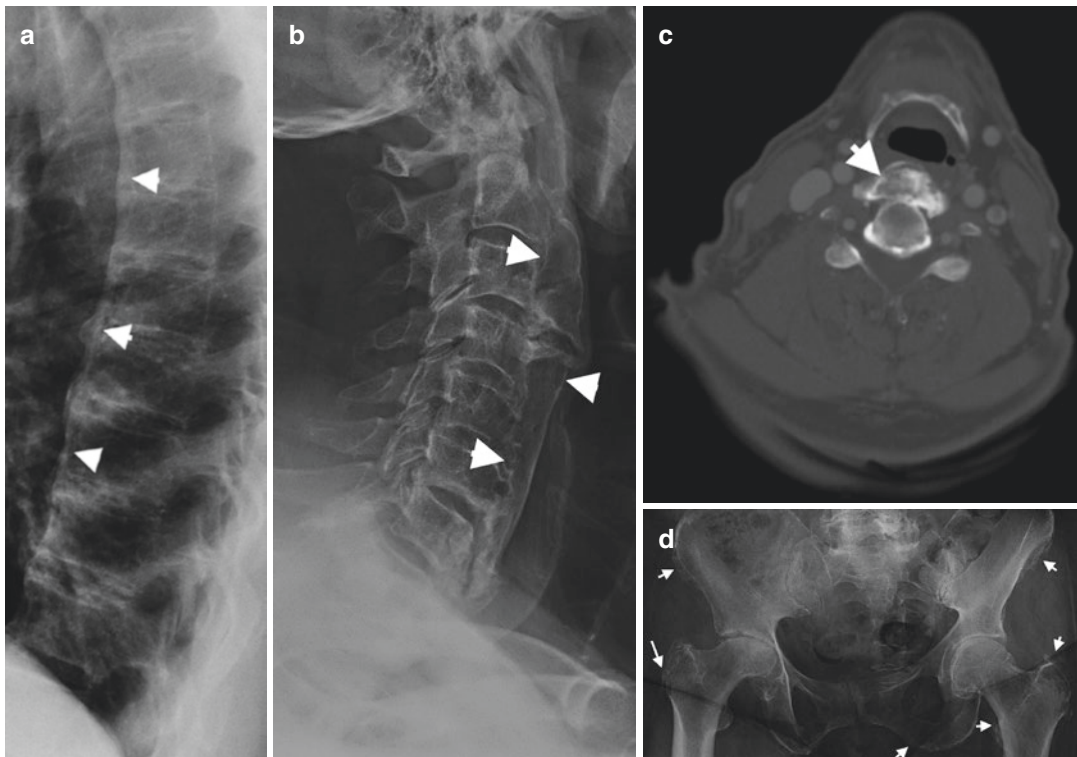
DISH lateral radiograph: (a) thoracic and (b) cervical spine demonstrating thin ossification thoracic and thick ossification anterior longitudinal ligament (arrowheads) in two different patients. (c) Axial CT same patient as (b) with cervical anterior longitudinal ligament
